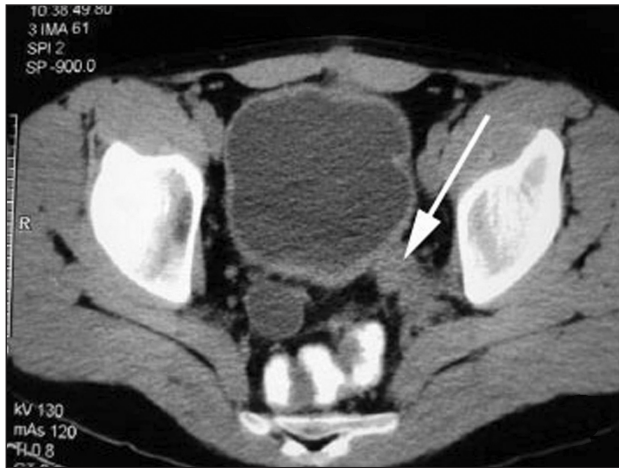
CT imaging showing reduction of the retroperitoneal mass (arrow) after 12 months of clinical therapy.
